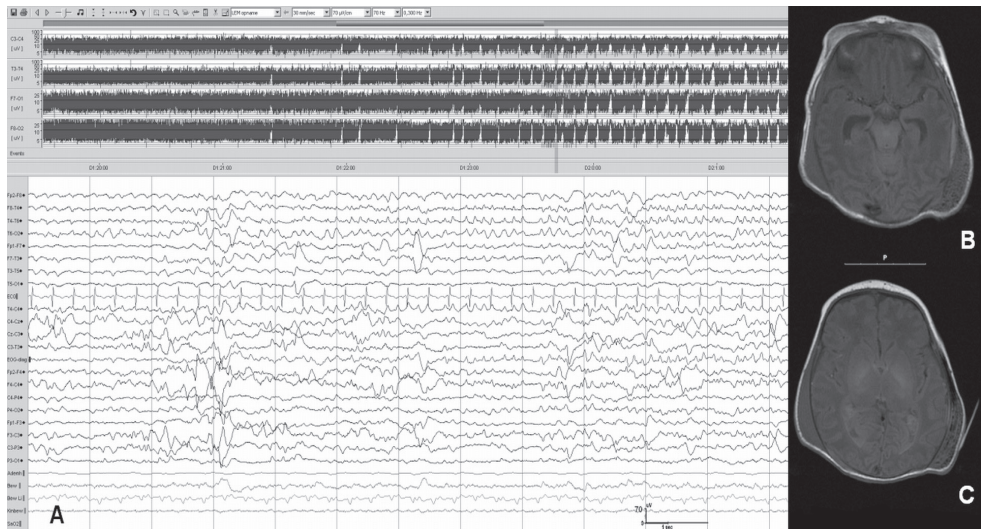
A: Rhythmic fast (5-6 Hz) seizure over right temporal region (patient no. 5, Table 1). The vertical grey bar over the aEEG trends corresponds to the EEG page displayed. EEG background was moderately abnormal (grade 2). Seizures (109 recorded) started 26 h post partum and continued for 18 h (duration of monitoring 96 h). B & C: MRI shows a mild left temporal subdural hemorrhage, a small extradural hematoma over right parieto-temporal region as well as small intraventricular hemorrhages, but no obvious parenchymal injury. Patient was normal at 2 year follow-up.
